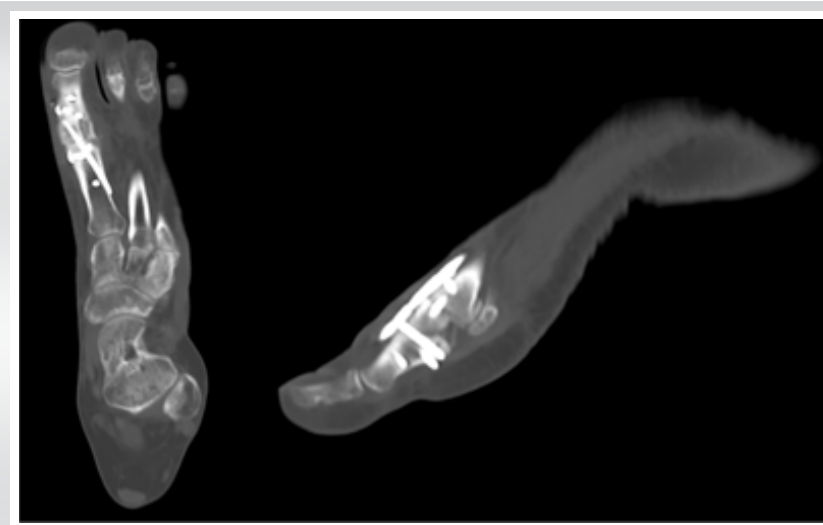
Six-month post-operative computed tomography demonstrating graft incorporation, bridging trabecular bone across the arthrodesis site, closure of the previous fusion gap and stable implant position.
